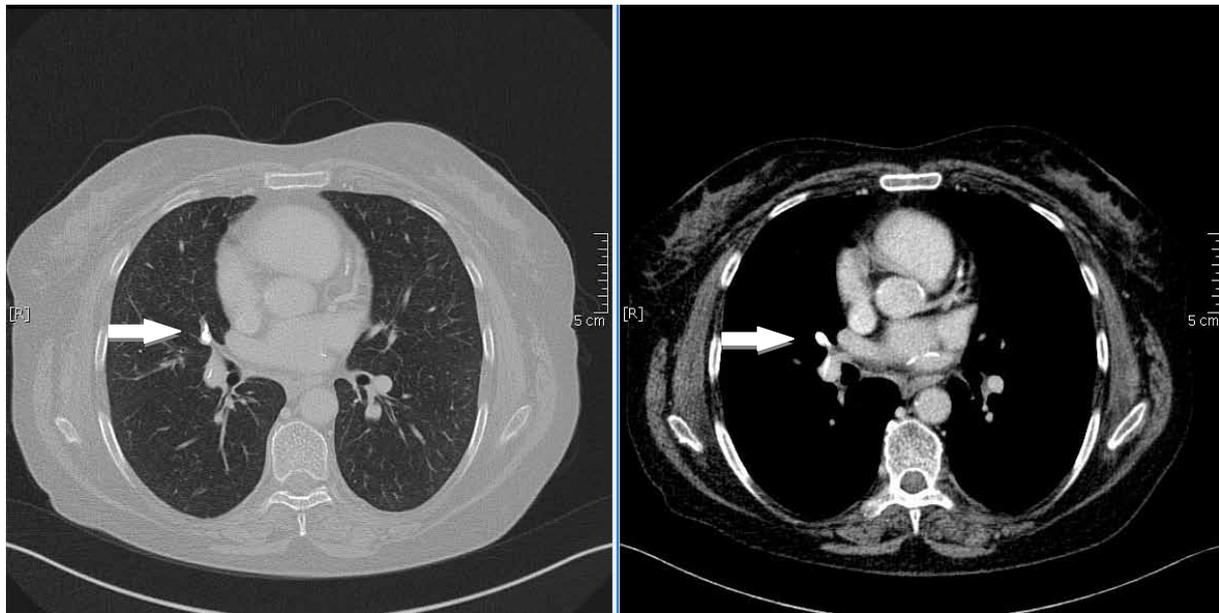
Contrast enhanced CT scan showed cement embolus in a peripheral right middle lobe pulmonary artery.
